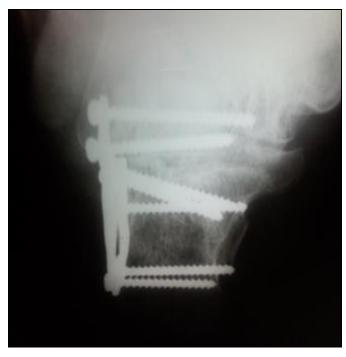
x-ray axial view calcaneum showing good reduction and no widening of calcaneum
